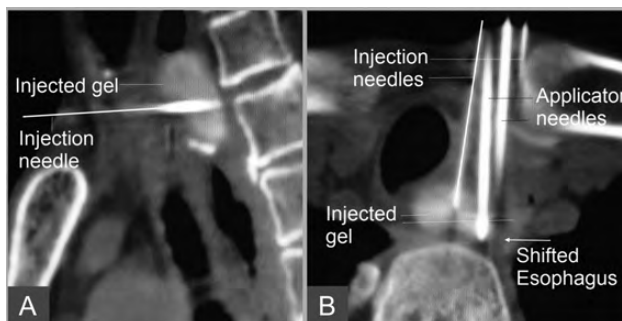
Sagittal (A) and axial (B) X-CT images show the space created by the injected gel, and shifting of a portion of the esophagus.
